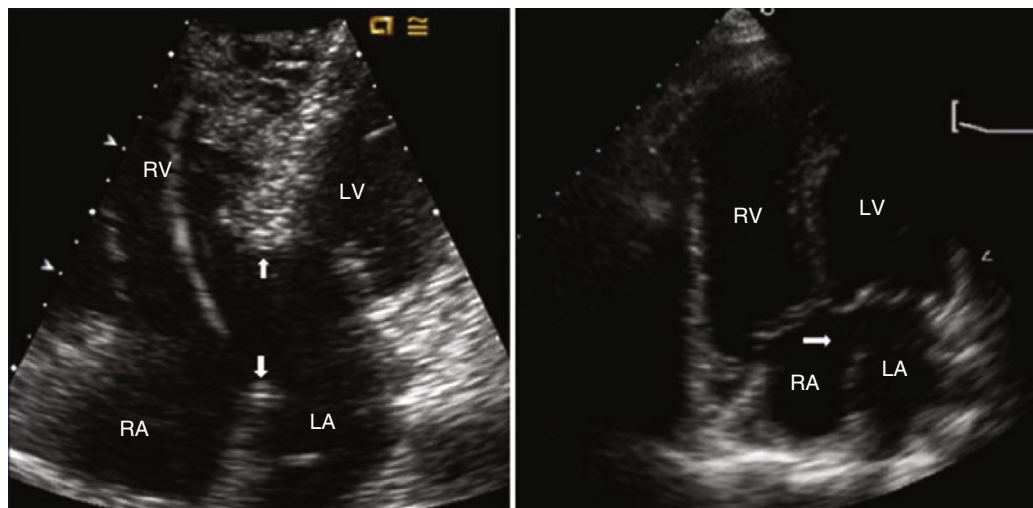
Apical four-chamber views showing complete (left) and partial (right) atrioventricular canal defects. In the left panel, *arrows* outline a large defect with atrial and ventricular components. In the right panel there is a primum ASD (*arrow*) with an intact ventricular septum. LA, Left atrium; LV, left ventricle; RA, right atrium; RV, right ventricle.
